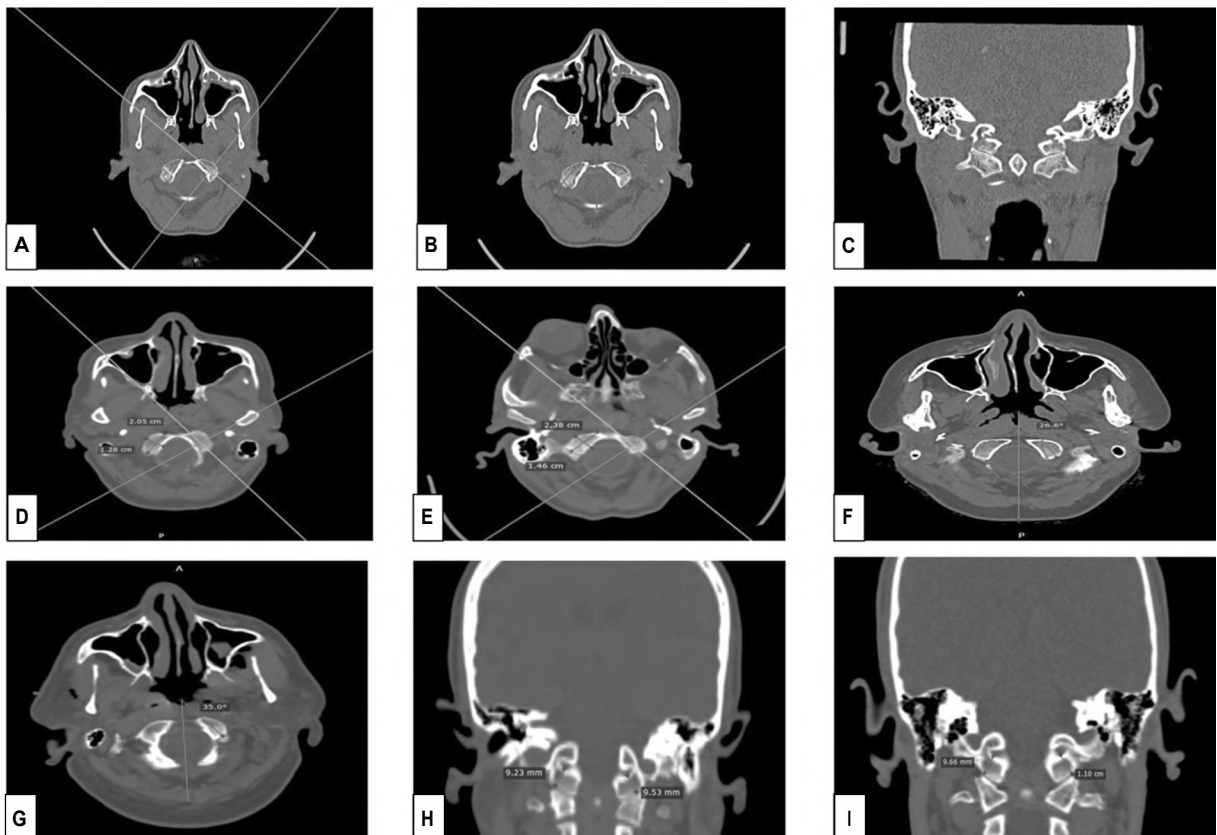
(A) An axial computed tomography image showing the OCL (the red line) and the OCW (the yellow line). (B): An axial computed tomography image showing how to measure the ACA represented in between the red arrows. (C): A coronal computed tomography image showing the CCH (the red lines). A MDCT image (axial cut) of (D): Female patient aged 33 years showing right OCL and W measurements. (E): 65 years old male patient showing right OCL and OCW measurements. (F): 21 years old female patient showing left ACA measurement. (G): A male patient aged 46 years old showing left ACA measurement. Coronal cut of (H): A female patient aged 50 years old showing right and left CCH measurements. (I): A 25 year old male patient showing right and left CCH measurements.
